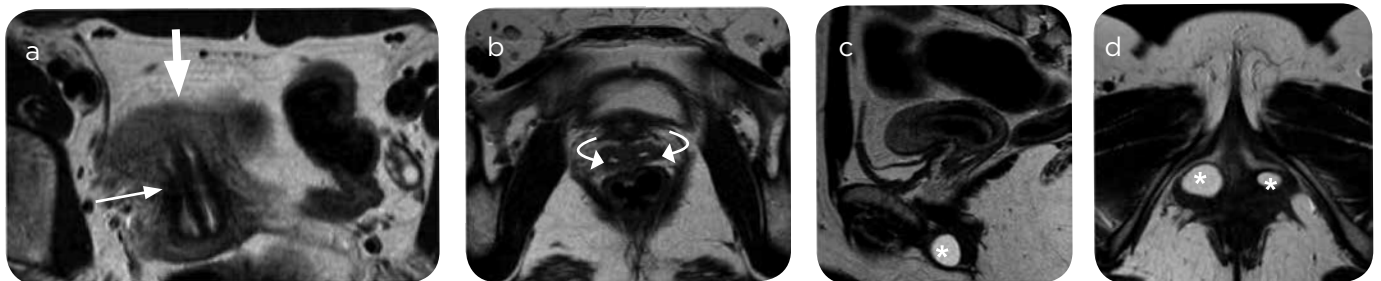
Complete septate uterus with septate vagina and two Bartolino cysts. a) TSE T2 coronal MRI oblique to the longitudinal uterine axis; b and d) Axial TSE T2 MRI; c) sagittal TSE T2. External contour of the convex fundus (arrow). Complete septum reaching the internal cervical orifice (thick arrow). Two vaginas are seen separated by vaginal septum (curved arrows). Bilateral cysts of Bartolino in both slopes of the vaginal introitus (asterisks).
